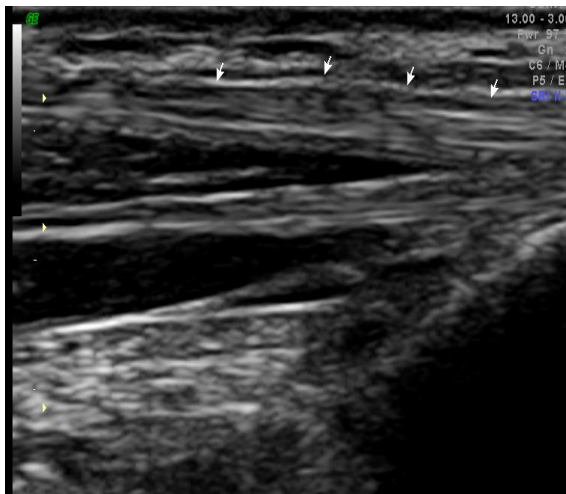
Arrows indicating the presence of Palmaris longus muscle, using ultrasound method (10-12 MHz linear probe).
